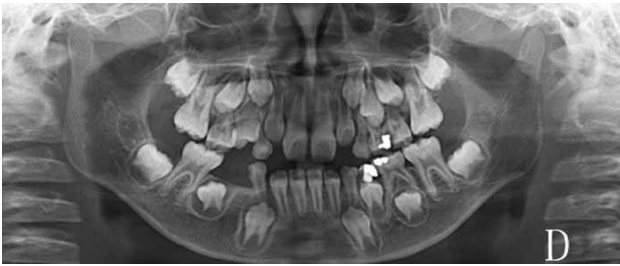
Panoramic radiograph of the patient at age 9y4m.
